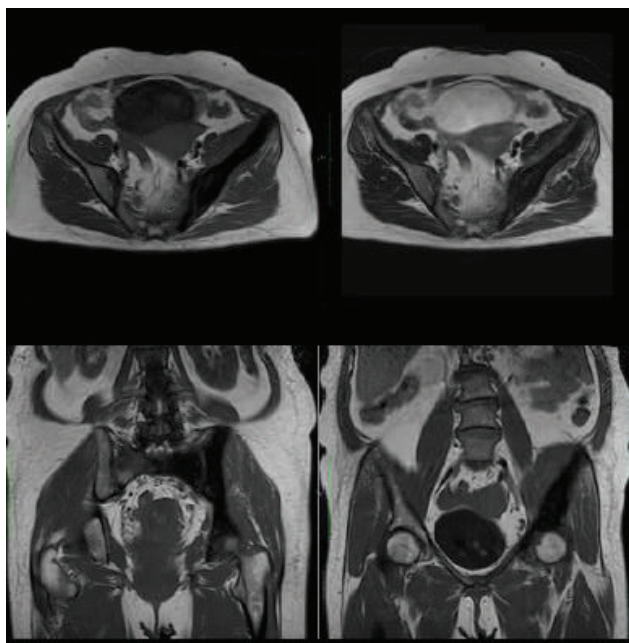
MRI of the hip revealed that there were extensive marrow signal abnormalities of left pubic bone with mild expansion seen in sacrum *predominantly left side seen at axial plane (above) and coronal plane (below)*. The findings were suggestive of primary or metastatic bone disease or other metabolic bone disorder like PDB.
